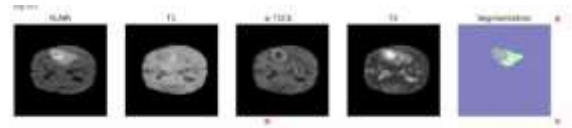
Example MRI Modalities – T1, T1c, T2, and FLAIR.
